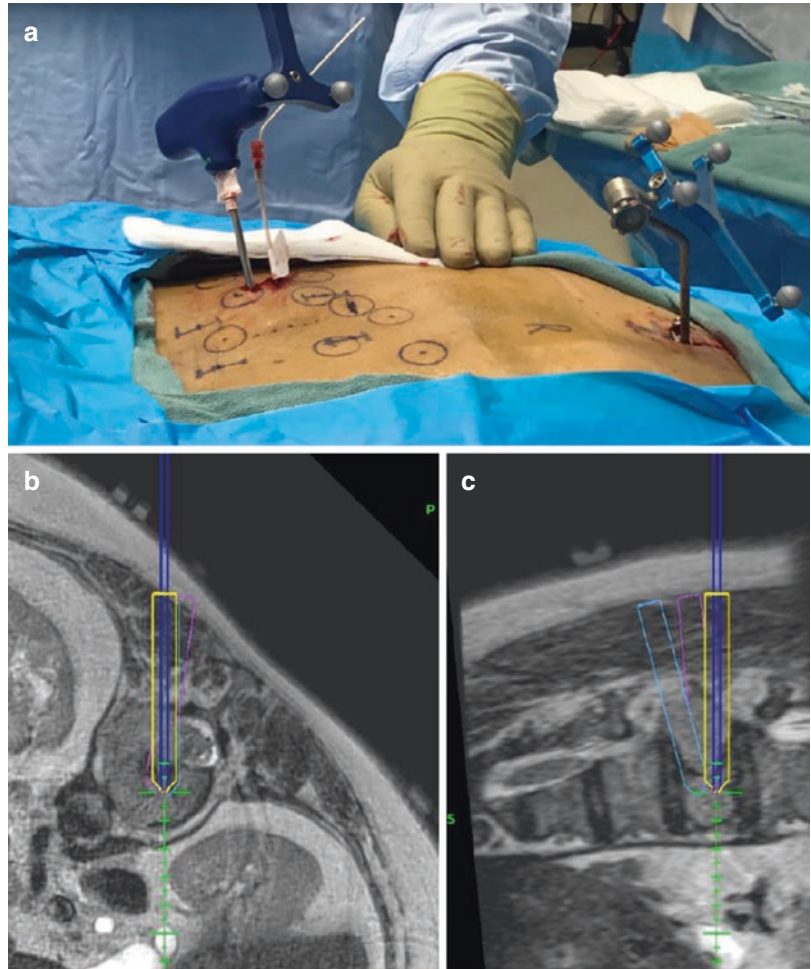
(a) Sterile reference array is attached to clamp under sterile conditions. A non sterile probe is used to perform surface matching of fiducials. (b) MRI 1mm axial cuts are obtained and transferred to standard navigation system for registration, accuracy of the image guidance is
